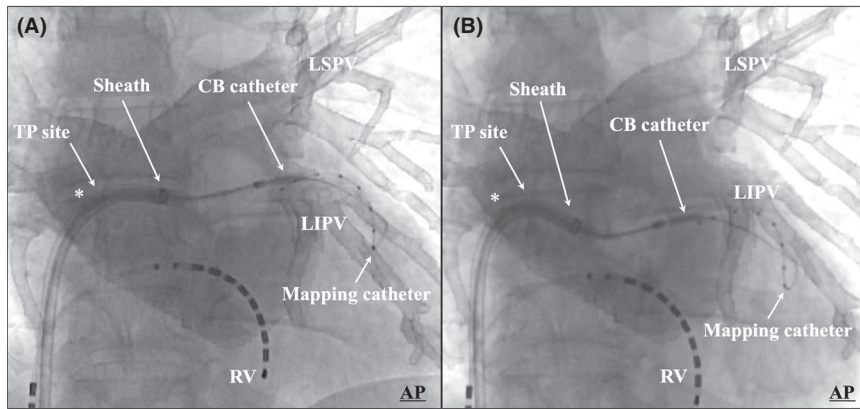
Fluoroscopic image merged with the preprocedural contrast-enhanced computed tomography image of the left atrium (LA) and pulmonary veins (PVs) at the beginning (A) and end of the standard hockey stick maneuver for cryoballoon left inferior PV (LIPV) isolation (B). The asterisks indicate the steerable segments of the sheath out of the LA. Abbreviations: AP, anteroposterior projection; LSPV, left superior PV; RV, right ventricle catheter; TP, transseptal puncture
